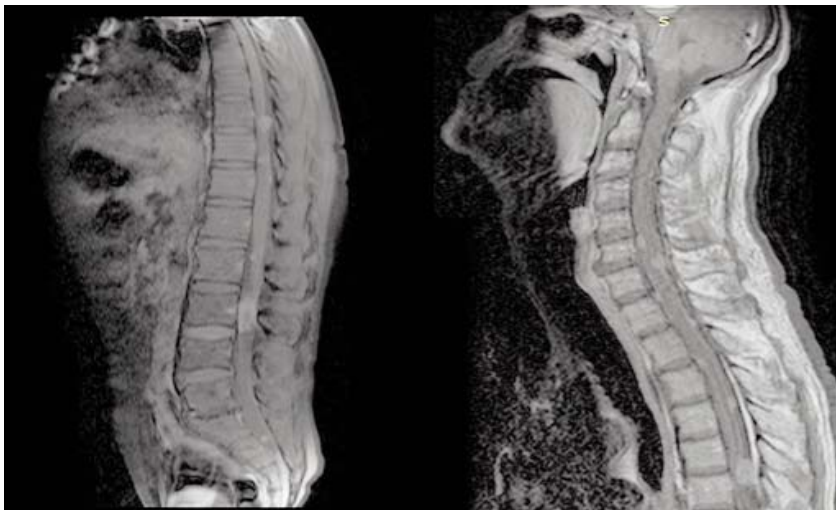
Follow-up MRI of the whole spine scan: Sagittal view T1+contrast showing leptomeningeal spread.
